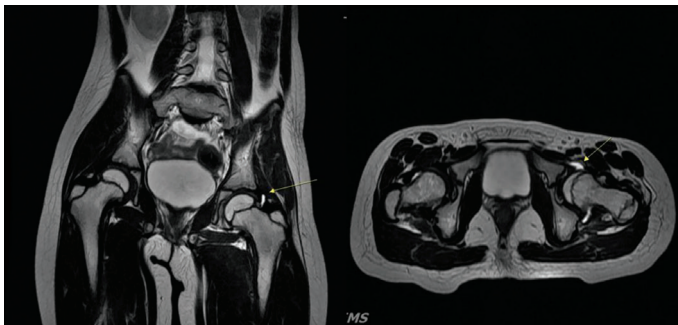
Magnetic resonance imaging (July 18, 2015). Both hips show an over coverage of the left acetabulum and prominent joint effusion in the left hip joint (arrow).
